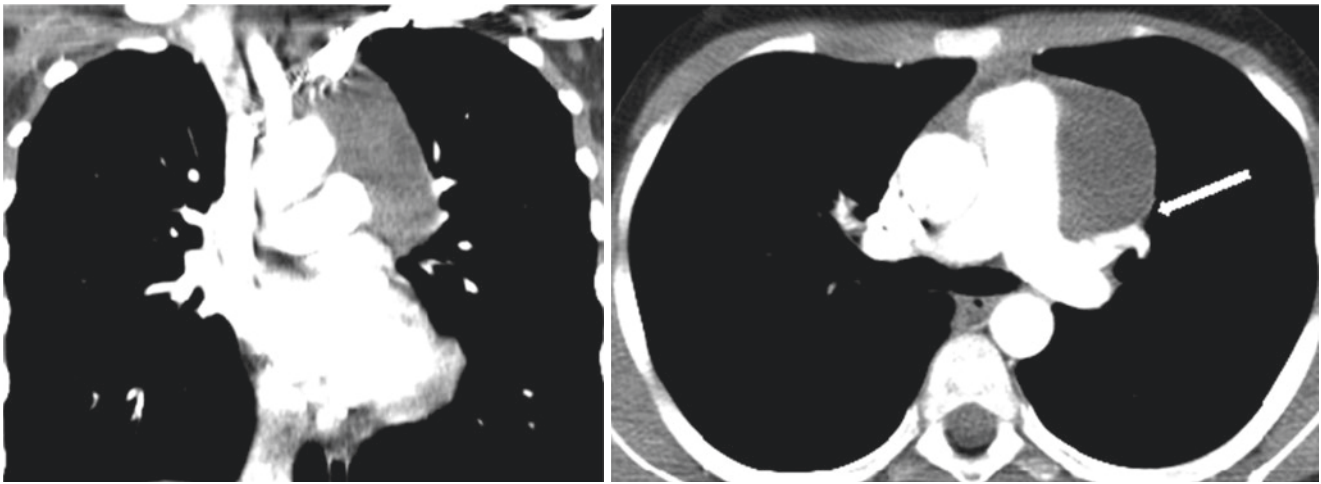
CT of the chest showing bronchogenic cyst near the left pulmonary hilum. The arrow demonstrates the long segment where the lesion was adherent to the left pulmonary artery requiring slow thoracoscopic dissection
